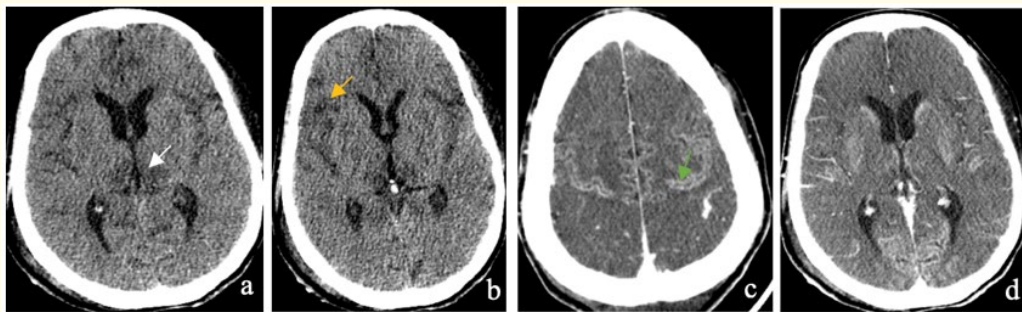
Non contrast enhanced brain CT (a) and (b) and contrast enhanced CT (c) and (d) in axial planes show bithalamic paramedian hypodensity (white arrow) and a temporal hypodensity (yellow arrow). We can also see a bilateral frontal gyral enhancement (green arrow). This imaging findings correspond to a hypoxic ischemic encephalopathy.
